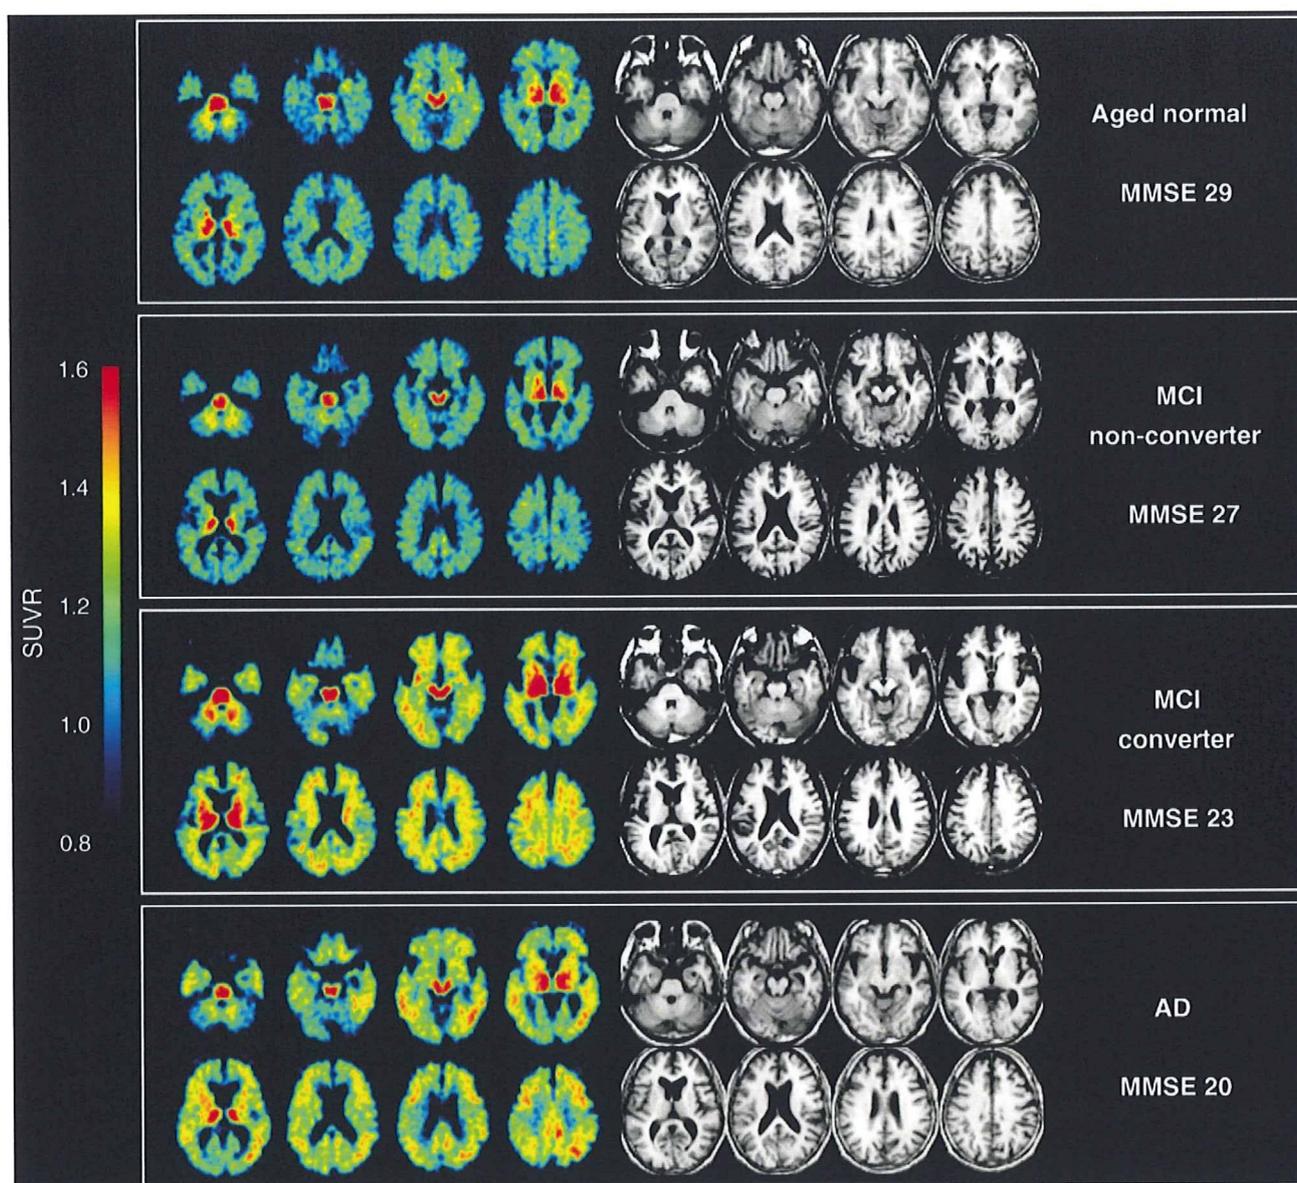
Representative images of [¹¹C]BF-227-PET SUVR between 20 and 40 min post-injection (left) and T1-weighted MRI (right) in a control subject, a MCI non-converter, a MCI converter and an AD subject. The degree of [¹¹C]BF-227 retention is shown by color intensity from yellow to red in the cortex.
